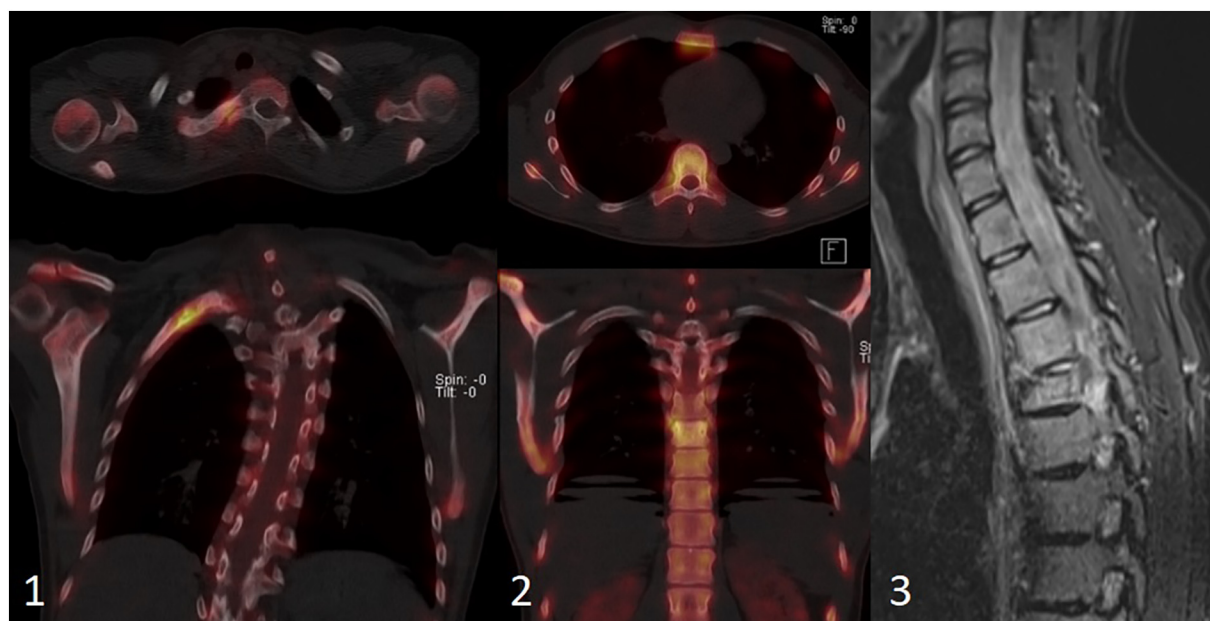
Imaging of all three cases. 1: SPECT images of case 1 showing increased bone metabolism in the right dorsal costae T2 and 3 and costovertebral joint; 2: SPECT images of case 2 showing moderately increased bone metabolism in the sclerotic vertebral body T8 continuing into the right pedicle; 3: T2 weighted MRI of case 3 shows edema around T4.
